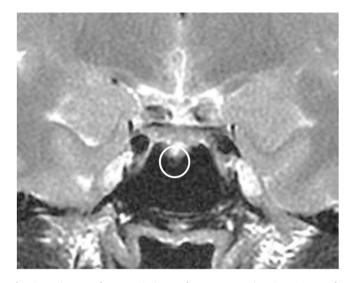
Brain MRI shows a pituitary adenoma measuring 4×2 mm. The persistence of amenorrhea and high PRL levels in blood lead to a diagnosis of prolactinoma. MRI: magnetic resonance imaging.
